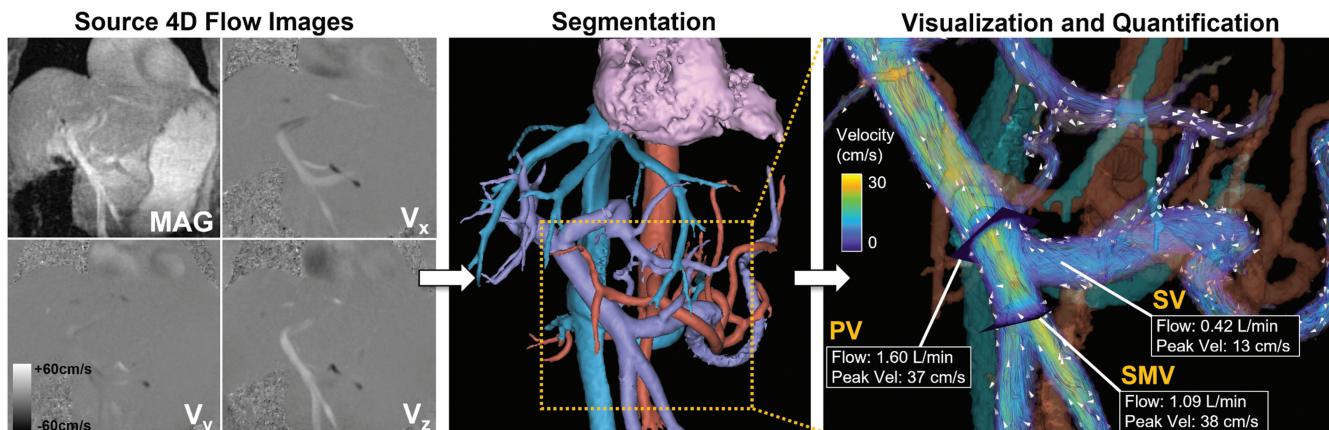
Visualization and quantification of abdominal hemodynamics using 4D flow MRI: (Left) Time-averaged velocity images (V_x , V_y , and V_z) and MAG images from a 4D flow MRI acquisition in a healthy volunteer shown for a single coronal slice. These source images are used to semi-automatically create a vessel segmentation of venous (blue), arterial (red), and portal (purple) vasculature (middle). Within the boundaries given by the segmentation, velocity information can be portrayed via color-coded velocity streamlines and quantified. White arrows depict the direction of blood flow in portal vasculature. Volumetric flow rates of the SMV and the SV add up ($0.42 \text{ mL/min} + 1.09 \text{ mL/min} = 1.51 \text{ mL/min}$) to the flow volume of the PV (1.6 mL/min) resulting in an error of 5.6% and confirming good data quality. MAG, magnitude; PV, portal vein; SMV, superior mesenteric vein; SV, splenic vein.
